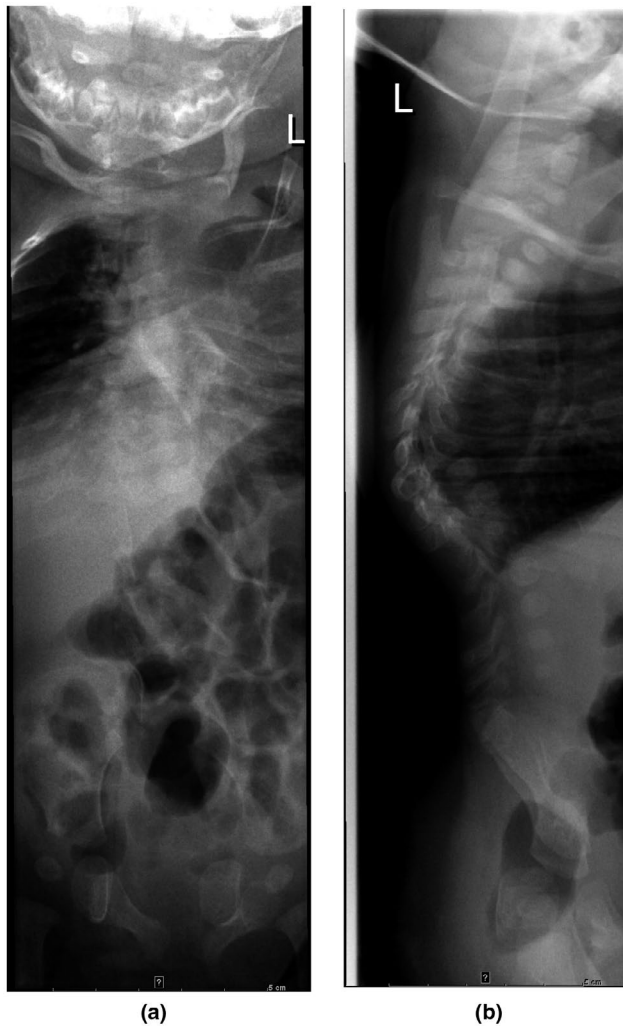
X-Ray spinal column at age 4 months, (a) a.p. view: lumbar vertebral bodies 1–3 appear rudimentary, lumbar vertebral bodies 4–5 and sacrum not discernible. (b) lateral view: fusion of the cervical spine, kyphosis of the thoracic spine, incomplete fusion of the vertebral bodies to the Procc. spinosi in the lower thoracic and the upper lumbar spine
